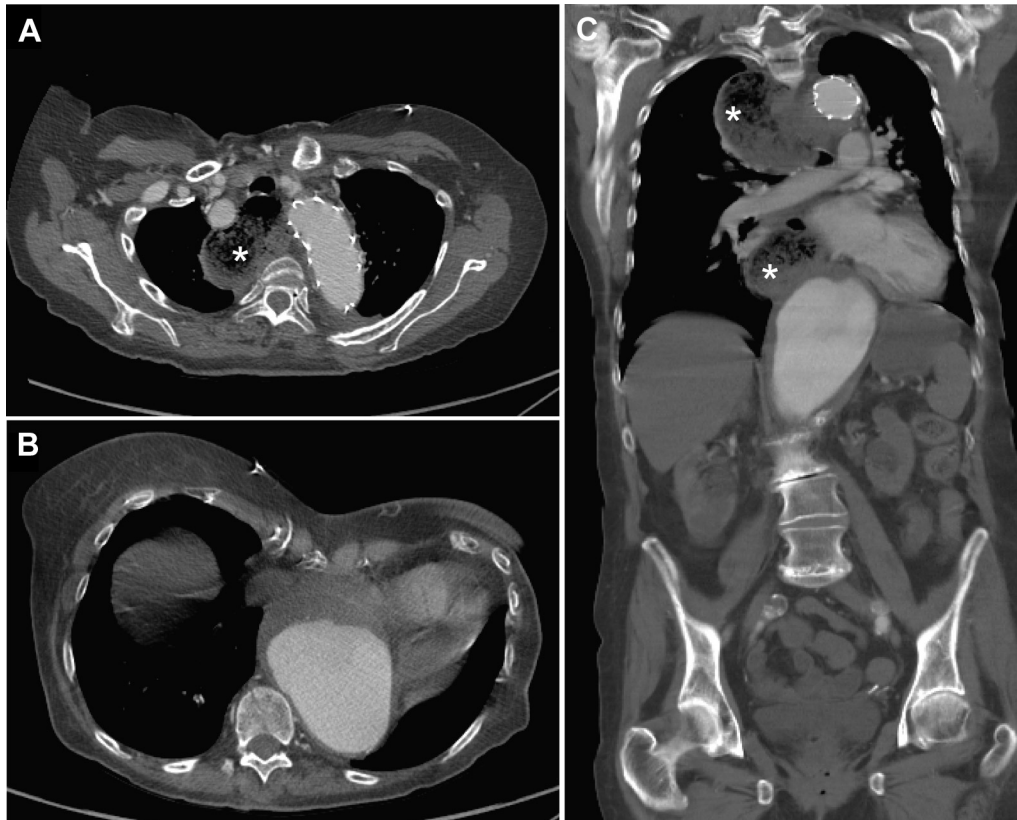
Computed tomography (CT) angiography demonstrating persistent thoracoabdominal aneurysm with associated esophageal dilation before thoracic endovascular aortic repair (TEVAR). Axial view in aortic arch (A) and diaphragm (B) and coronal view (C). The esophagus is marked with an *asterisk*.
